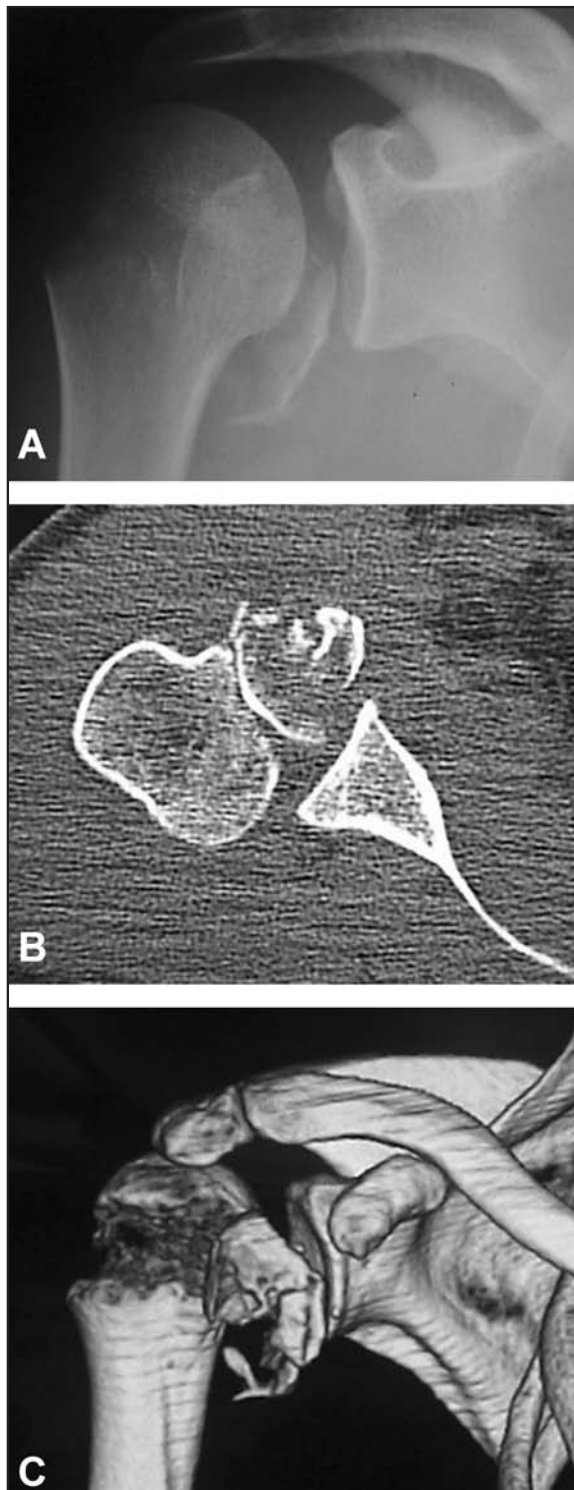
Fracture classification cephalodiaphyseal/T/t (CD/T/t). Fracture of three fragments with conservation of the cephalodiaphyseal relationship and fracture between both tuberosities. This type of fracture is not described in any current classification or in Hertel's graph. (A) A fragment can be seen in the gleno-humeral joint in this X-ray view. (B) A CT scan shows a bigger anterior articular fragment. (C) A 3-D image shows the conservation of the cephalodiaphyseal relationship with a fracture of the tuberosities. Images provided by Dr. C. Torrens of Hospital del Mar (IMAS-IMIM), Barcelona, Spain.
